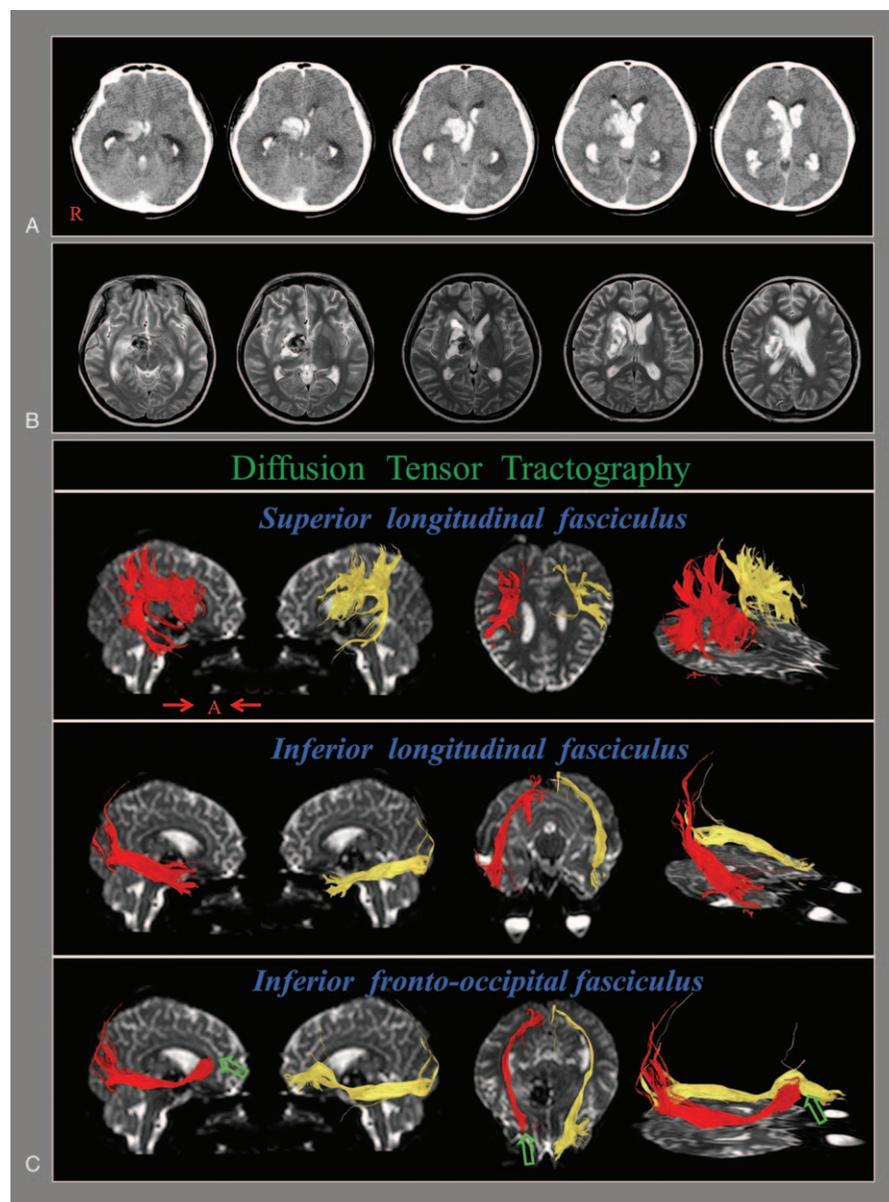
A, Brain computed tomography images at the onset show intracerebral hemorrhage (right thalamus), intraventricular hemorrhage, and subarachnoid hemorrhage. B, T2-weighted brain magnetic resonance images at 7 weeks after onset reveal leukomalactic lesions in the right thalamus and subcortical white matter. C, Results of diffusion tensor tractography. On the configuration of the 7-week diffusion tensor tractography, the right superior longitudinal fasciculus and inferior longitudinal fasciculus are well-reconstructed without definite injury compared with those of the left side. However, the right inferior fronto-occipital fasciculus is discontinued in the anterior portion around the frontal lobe (green arrow).
